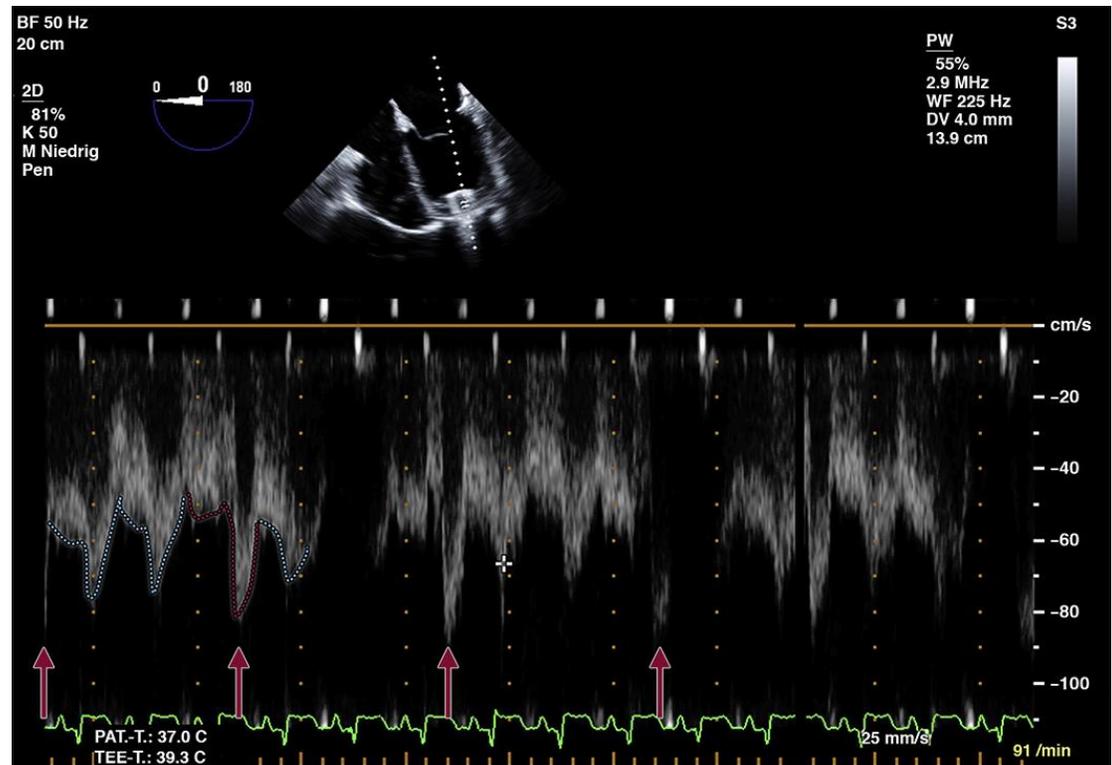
Transesophageal echo: pulsatility of blood flow. The pulsed wave Doppler shows the heart's cycle and pump-augmented baseline inflow into the device. Within 15 ms, pump speeds are decreased by 2,000 rpm from baseline, then increased by 4,000 rpm before being adjusted back to previously programmed values. From Magunia et al.(4), with permission.
